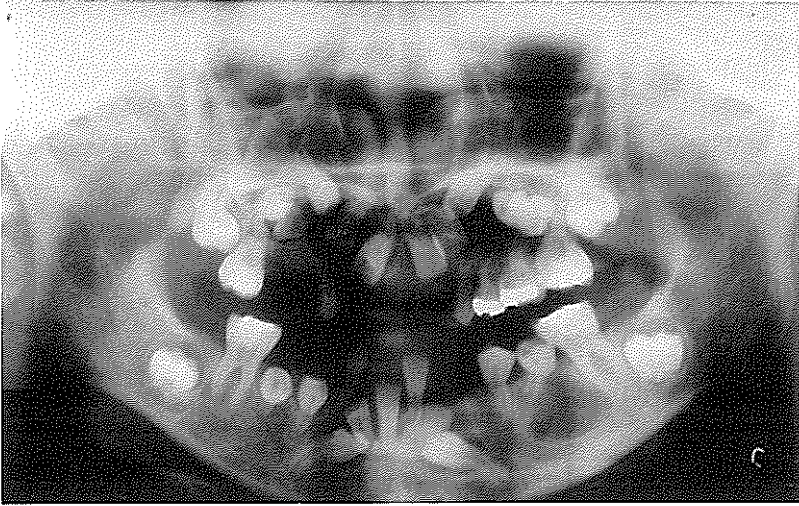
A Panoramic Radiograph of a 12-Year-Old Female Yusho Patient
